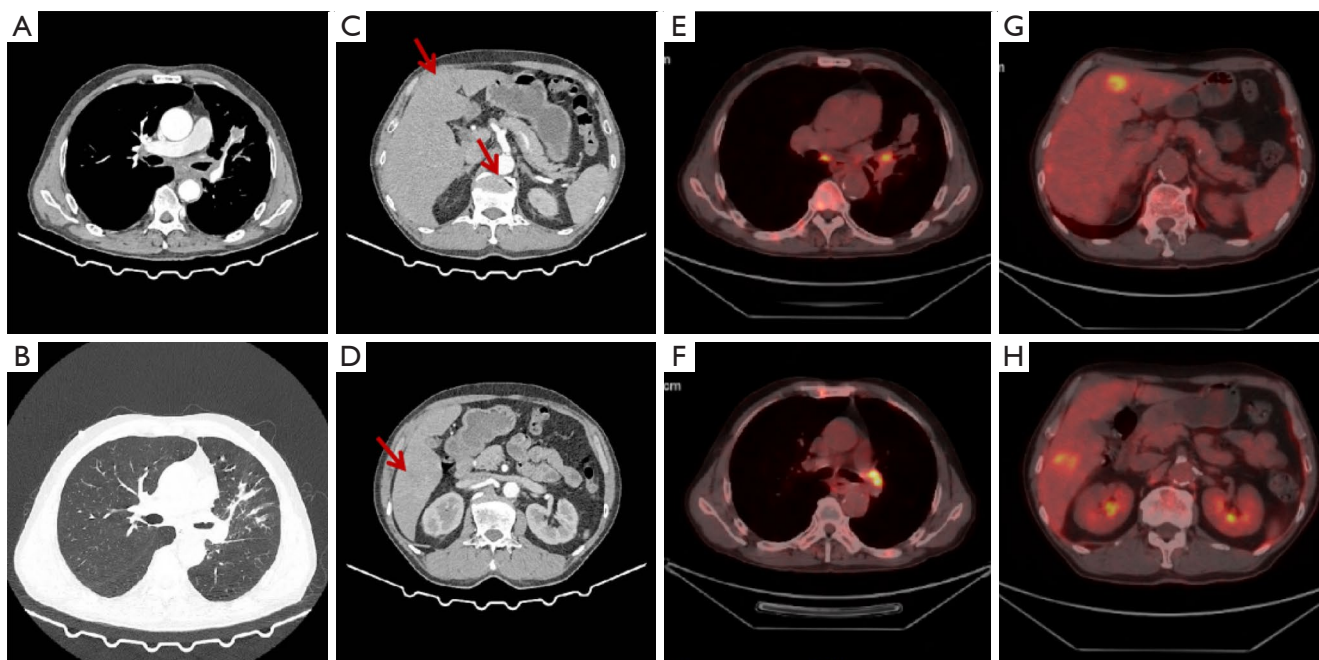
Chest CT and the positron emission tomography-CT before the chemotherapy. (A,B,E,F) The left hilar was occupied by the tumor tissue and part of the bronchi in the left upper lobe were obstructed. (C,D,G,H) Liver and bone metastasis. The arrows indicated the liver metastatic lesions. CT, computed tomography.
